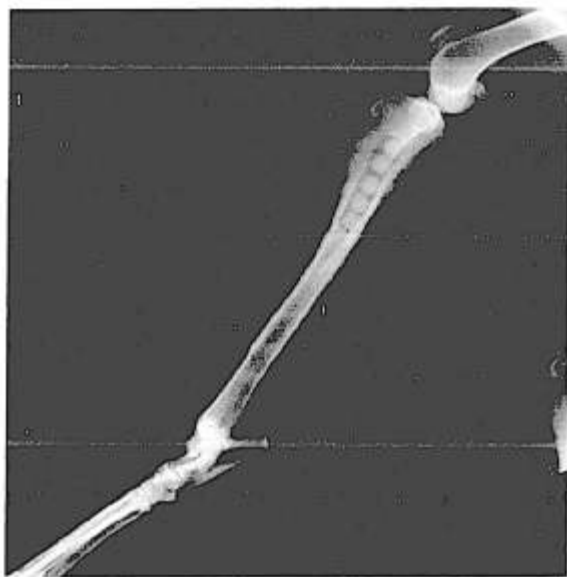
Roentgenogram of the left tibia showing five antibiotic-impregnated polymethylmethacrylate (PMMA) beads placed in the surgical defect. Fluid accumulates around the implanted PMMA beads in the seroma cavity.
